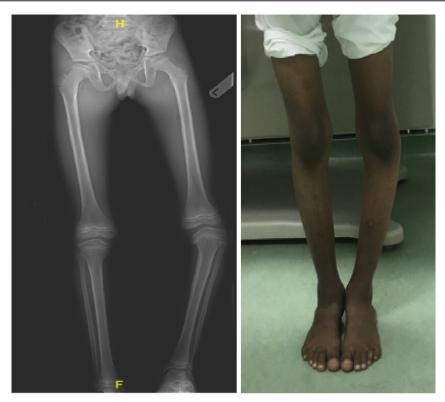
Pre-operative clinical and radiographic appearances showing left genu varus (Langenskiold stage IV).
